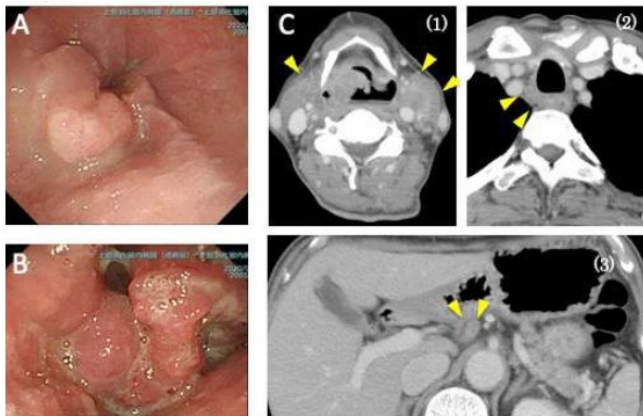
A: Upper gastrointestinal endoscopy revealed that the esophageal lumen was filled with necrotic components from the primary esophageal cancer. B: Upper gastrointestinal endoscopy revealed that the neoplastic lesion spread from the hypopharynx to the larynx broadly. C: Computed tomography (CT) showed multiple swollen lymph nodes in the neck (1), mediastinum (2), and abdomen (3).
